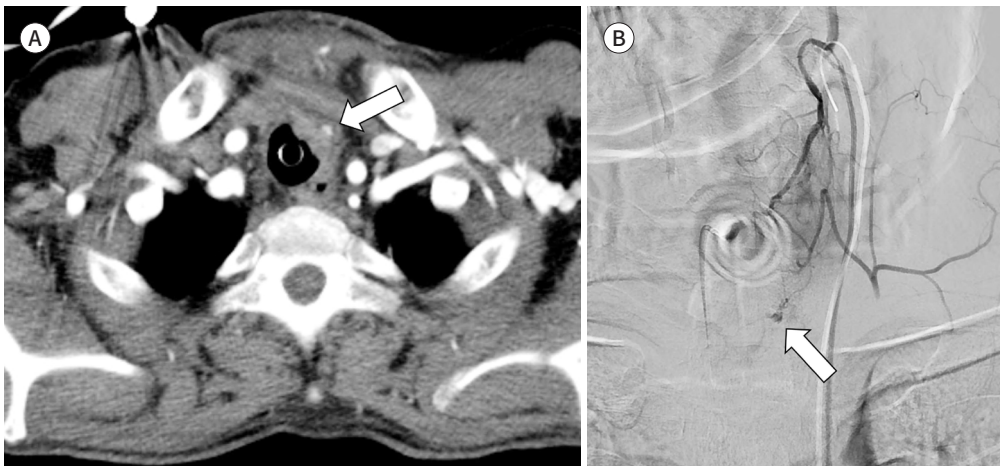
Representative CT and angiography images for case 2.
